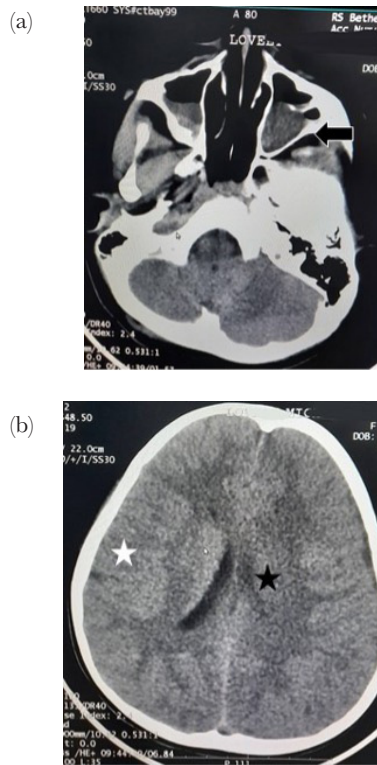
The axial non contrast CT scan of the head on September 24, 2020, showed the mucosal thickening of the maxilla antrum (arrow) and nasal cavity (a) and the sign of cerebral edema (b) like narrowed ventricles (black asterisk) and less prominent sulcus and gyrus (white asterisk)
